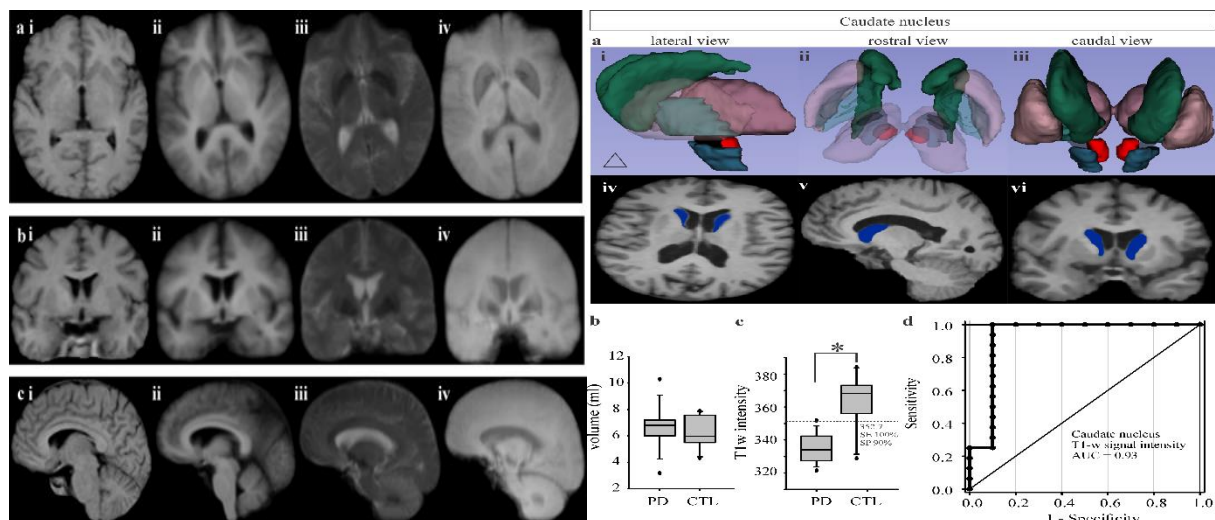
(left). MRI brain atlas. (I) Probabilistic average images from population, T_1w , $N=10$. (II) Probabilistic average images from PD patients, T_1w , (III), T_2w PD and (IV) SWI PD, $N=16$. Figure 2 (right). Volume and intensity analysis of the caudate nucleus. Sample PD-brain 3D surface-renderings of the basal ganglia (CN, dark green;
